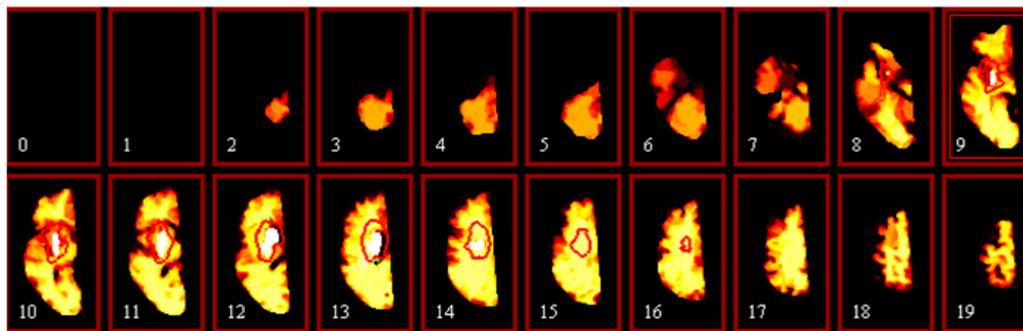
PM of multi-parameters: ADC and DWI for 20 slices with reference segmented results at days 30 (Patients171).
